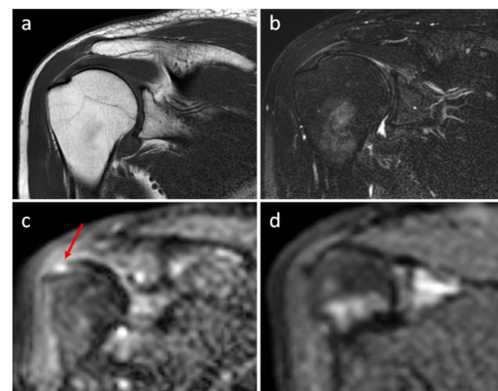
A 66-year-old patient with shoulder pain. (a) T1WI (b) FS-T2WI informs the partial thickness rotator cuff tear and (c) DWI (red arrow) prove it. Compared with the partial thickness rotator cuff tear patient, we regard DWI of 21-year-old normal person (d) as a control.
